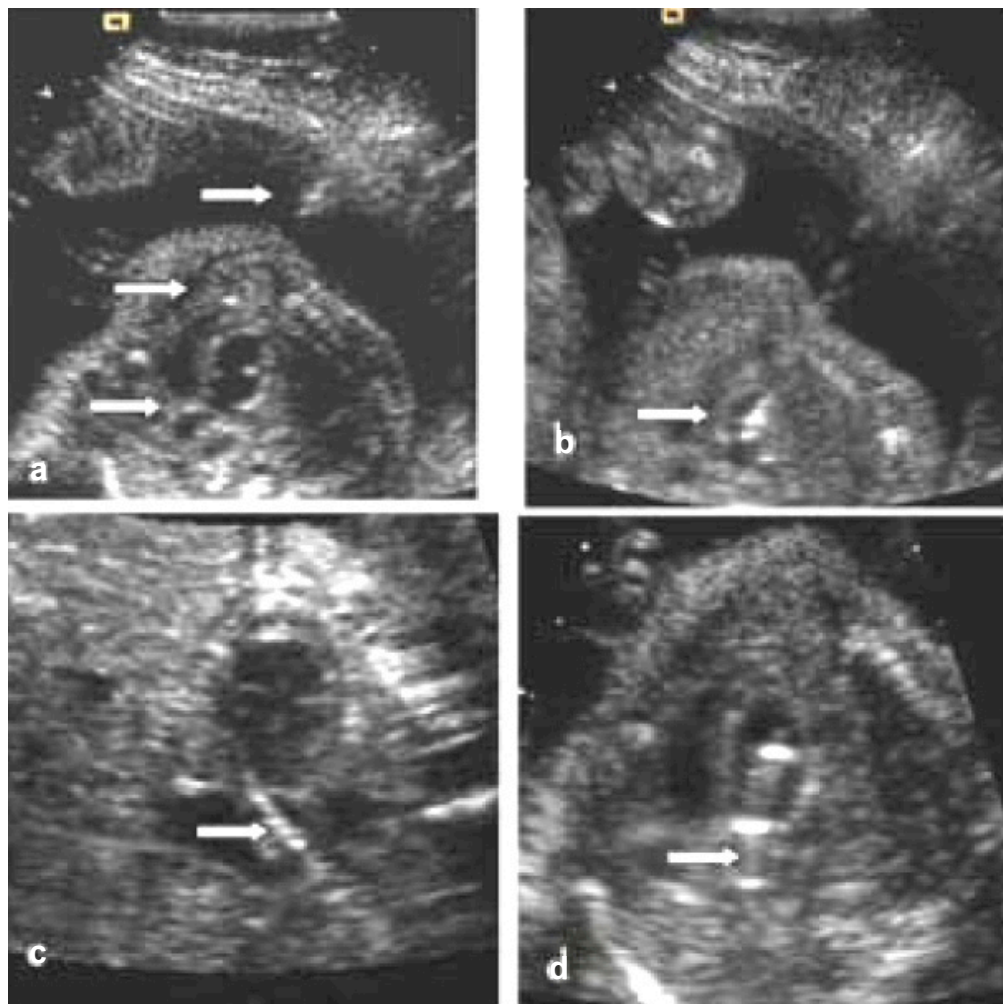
Transabdominal ultrasound imaging of fetal aortic valve dilation. a) The introducer cannula is seen advancing through the myometrium and into the amniotic cavity (first arrow) toward the fetal chest wall (second arrow), with the aortic valve in view (third arrow). b) The needle is advanced into the LV cavity until the tip is in the subaortic region. c) The wire is advanced through the valve and into the ascending aorta. d) The balloon is advanced over the wire and inflated while straddling the valve.
